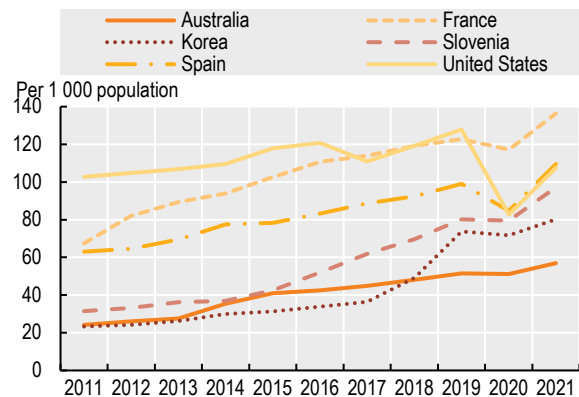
Trends in CT exams, selected countries, 2011-21
